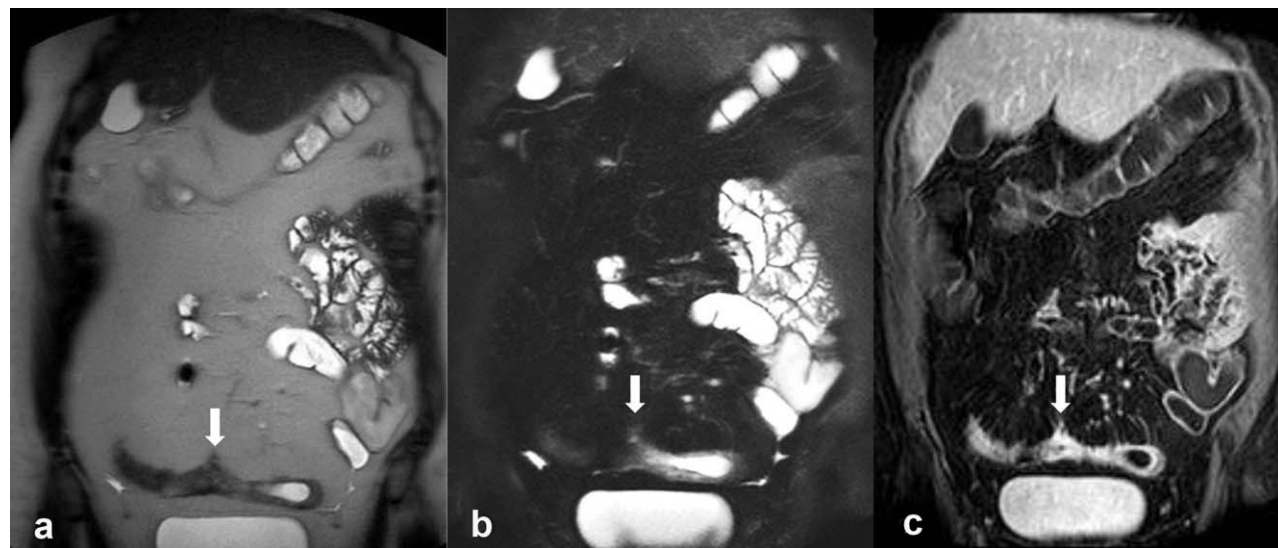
A 55-year-old woman patient with active CD. (a) TSE T_2 -weighted MR images; (b) T_2 -weighted SPAIR MR images with fat suppression; (c) THRIVE with fat suppression MR images acquired in the coronal plane after injection of gadobenate dimeglumine during the arterial phase. Diffuse thickening of the ileal wall with evidence of sinus tract (arrow) at unenhanced MRE both at TSE T_2 -weighted (a) and T_2 -weighted SPAIR MR images (b). The sinus is also clearly evident at contrast-enhanced MRE (c). There was agreement between unenhanced MR and contrast-enhanced MRE in defining active inflammation which was confirmed by endoscopy (CDEIS = 18).
